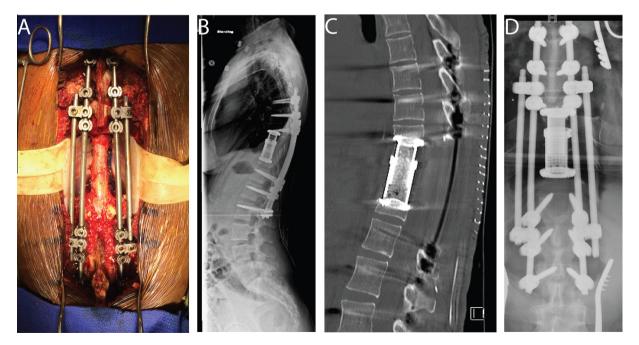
Intraoperative and postoperative imaging. (A) Photograph demonstrating *en bloc* resection of the lesion centered at the T10 vertebral body with posterolateral arthrodesis from T7–L2 with anterior titanium expandable cage. Silastic sheath (Dow Corning, Midland, MI, USA) in place to protect great vessels and lung anterior to the spinal canal. (B) Lateral plain radiograph, (C) sagittal CT scan and (D) anteroposterior plain radiograph demonstrating instrumentation.
